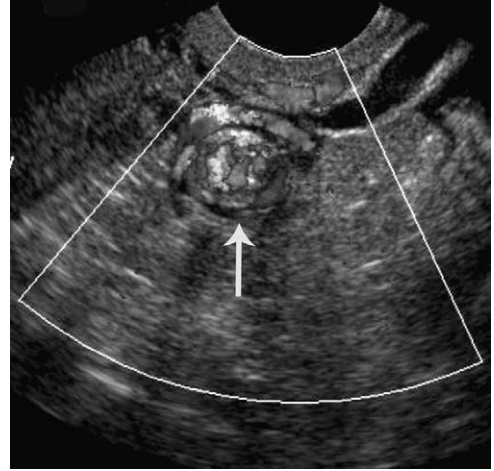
“Whirlpool sign” of ovarian torsion. Transvaginal ultrasound with color Doppler (shown in black and white) shows the corkscrew appearance of the twisted vascular pedicle (arrow).
